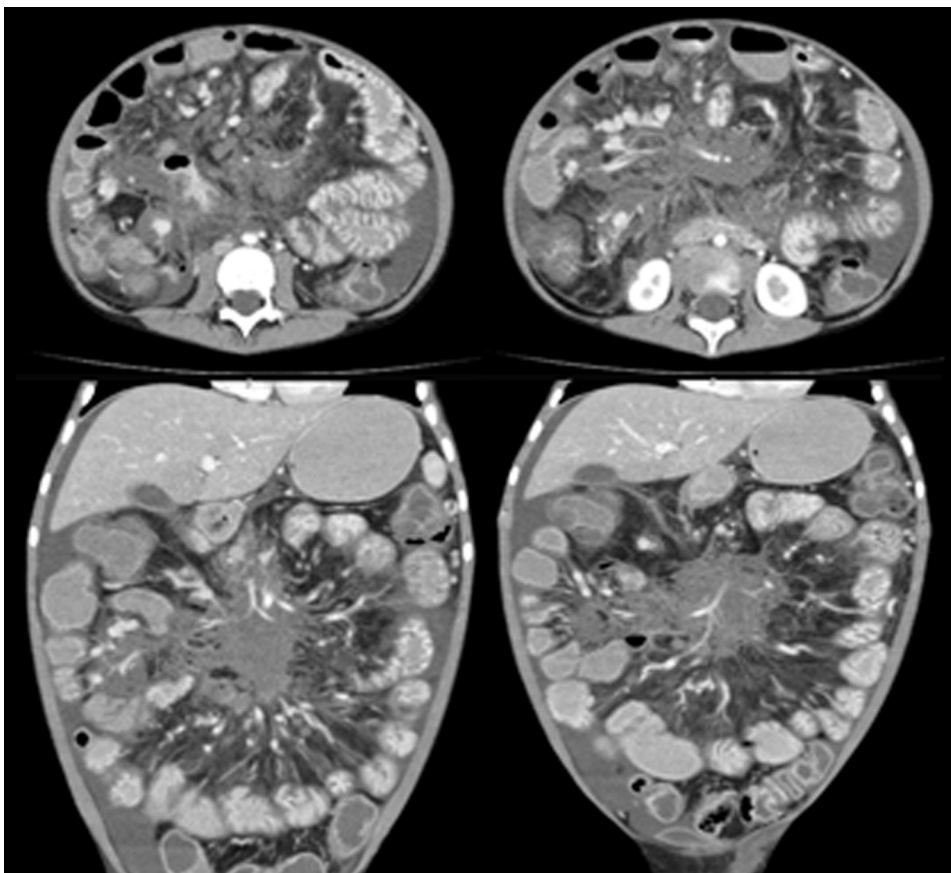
Computed tomography scan showing the tumor involving celiac and mesenteric axis, pancreas, and liver hilum.
